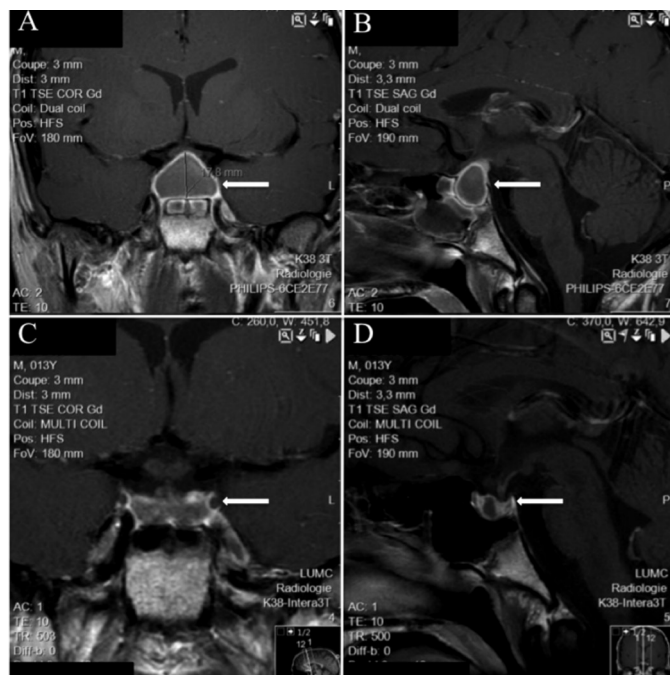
Magnetic resonance imaging: T1-weighted imaging. At presentation: coronal (A) and sagittal (B) view showing rim enhancement and sphenoid sinus mucosal thickening. Three months later: coronal (C) and sagittal (D) view showing substantial mass reduction
